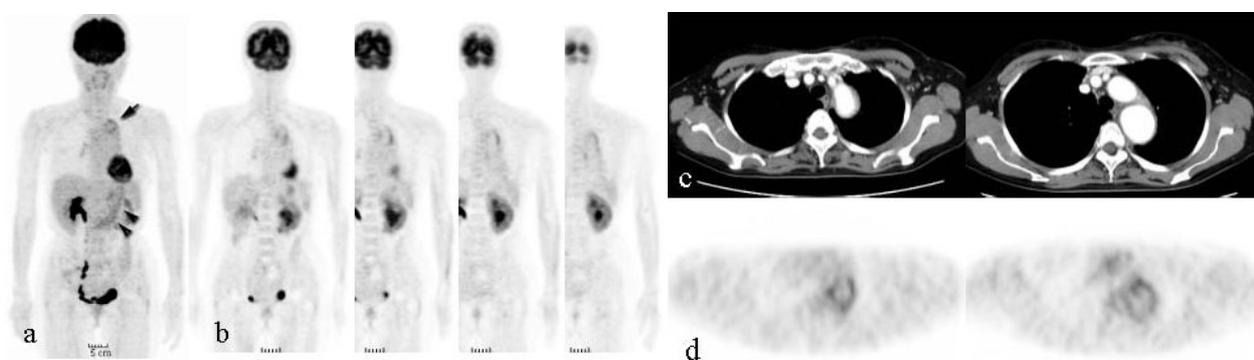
a, b: FDG-PET images demonstrate abnormal FDG accumulation in the aortic arch. Moderate diffuse uptake is seen in the stomach (*arrowhead*). No other abnormal FDG uptake is seen. c, d: CT images show a dilated thoracic aorta with wall thickening. FDG-PET demonstrates intense uptake corresponding to the aneurysmal wall. (c, contrast-enhanced CT; d, FDG-PET axial views corresponding to the CT images.)
